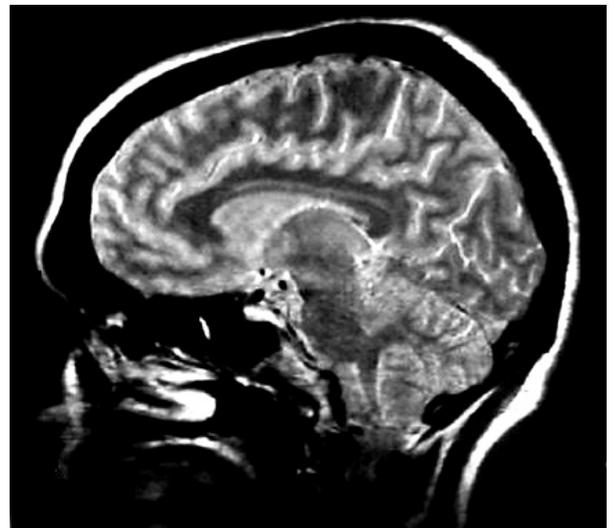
An MRI of the brain in the sagittal plane. Note the main branches of the anterior and posterior cerebral circulation
